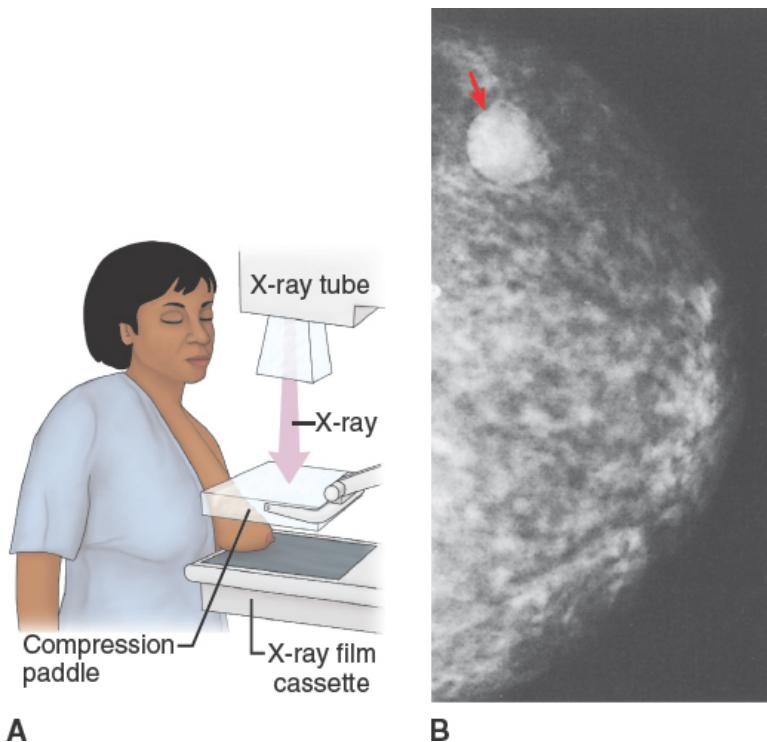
• The mammography procedure (A) relies on x-ray imaging to produce the mammogram (B), which in this case reveals a breast lump (see arrow).
